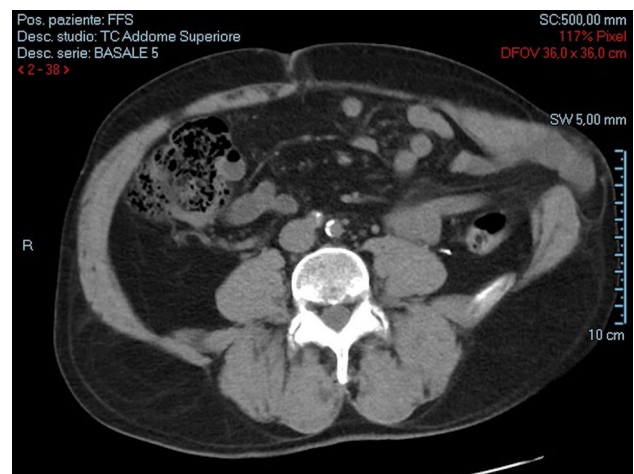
Preoperative CT imaging
